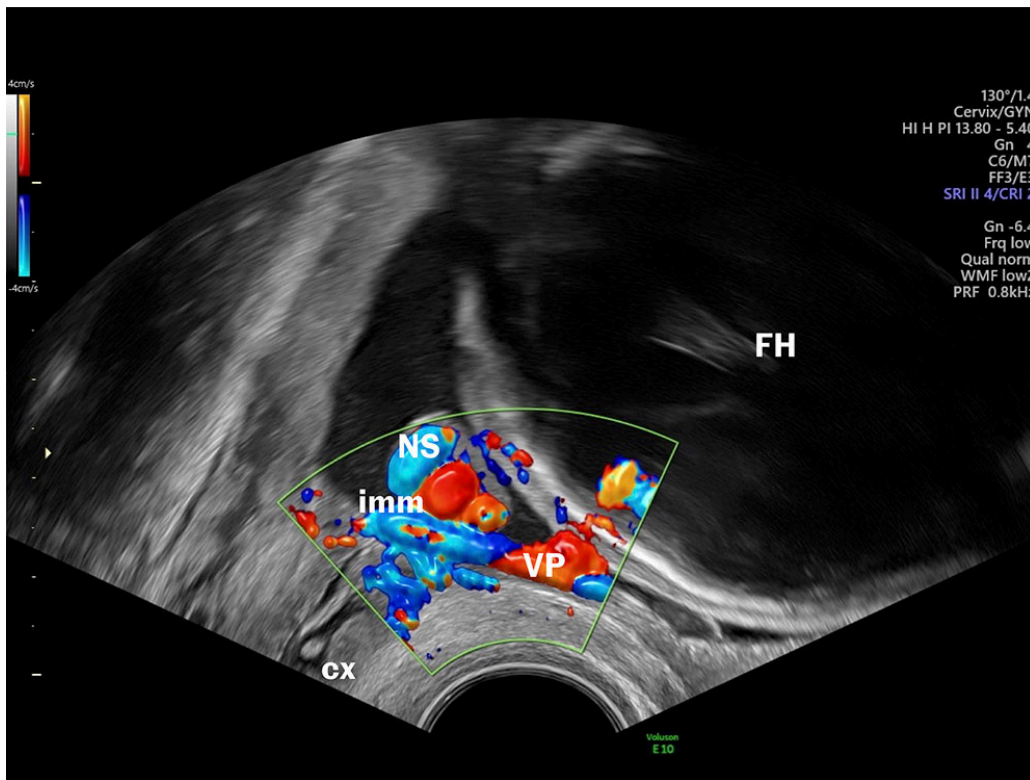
Vasa previa. Ultrasound image and video from a transvaginal ultrasound examination showing the cervix, lower edge of the placenta, fetal head, umbilical cord and blood vessels lying across the membranes, adjacent to the opening of the cervix. imm=internal cervical os, VP=vasa previa, NS=umbilical cord, cx=cervix, FH=fetal head
